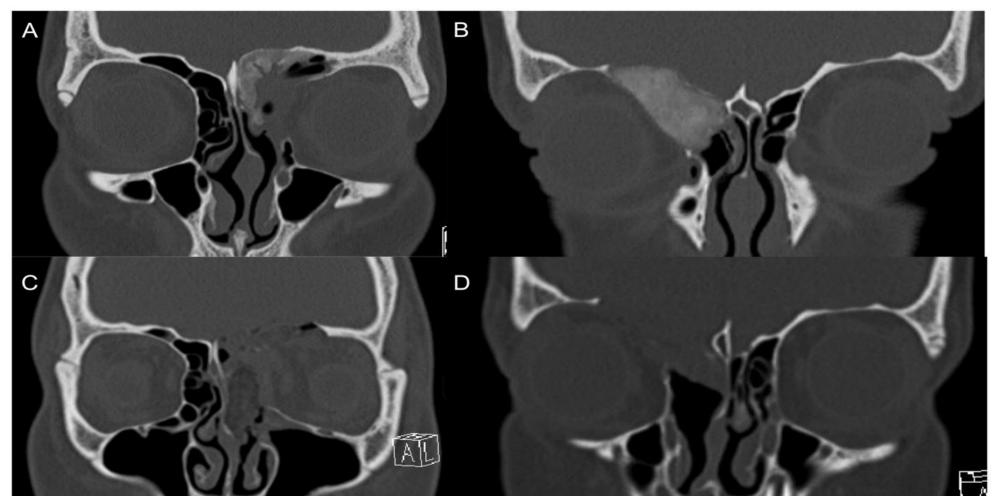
A and B) Representative preoperative CT showing a frontal sinus and orbital skull base mass. (C and D) Representative postoperative CT showing complete resection of respective lesions via a multiportal endoscopic endonasal and transorbital neuroendoscopic approach.
